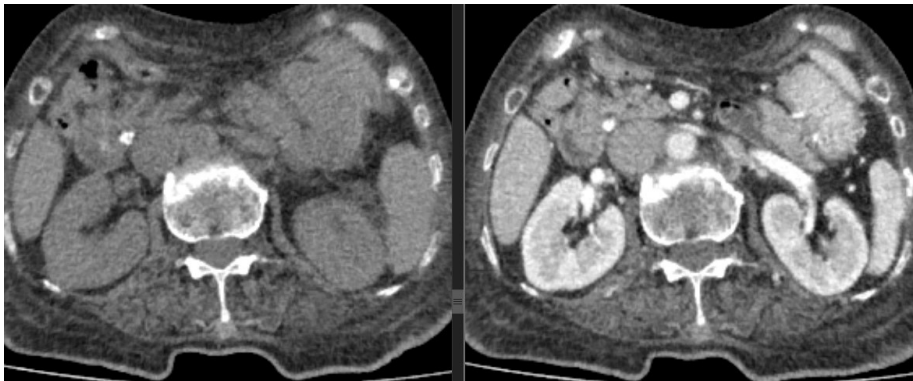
Above axial contrast and non-contrast CT images showing radio dense choledocholithiasis in distal CBD.
